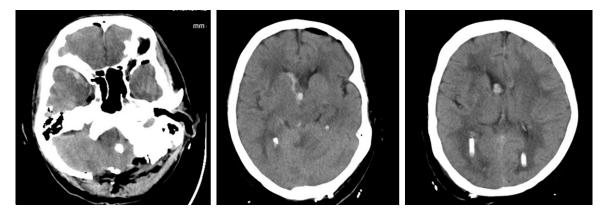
Pre operative CT scan. Representative pre-operative CT scan of a patient in it. showing a posterior fossa haemorrhage with associated hydrocephalus and blood in the ventricles.
